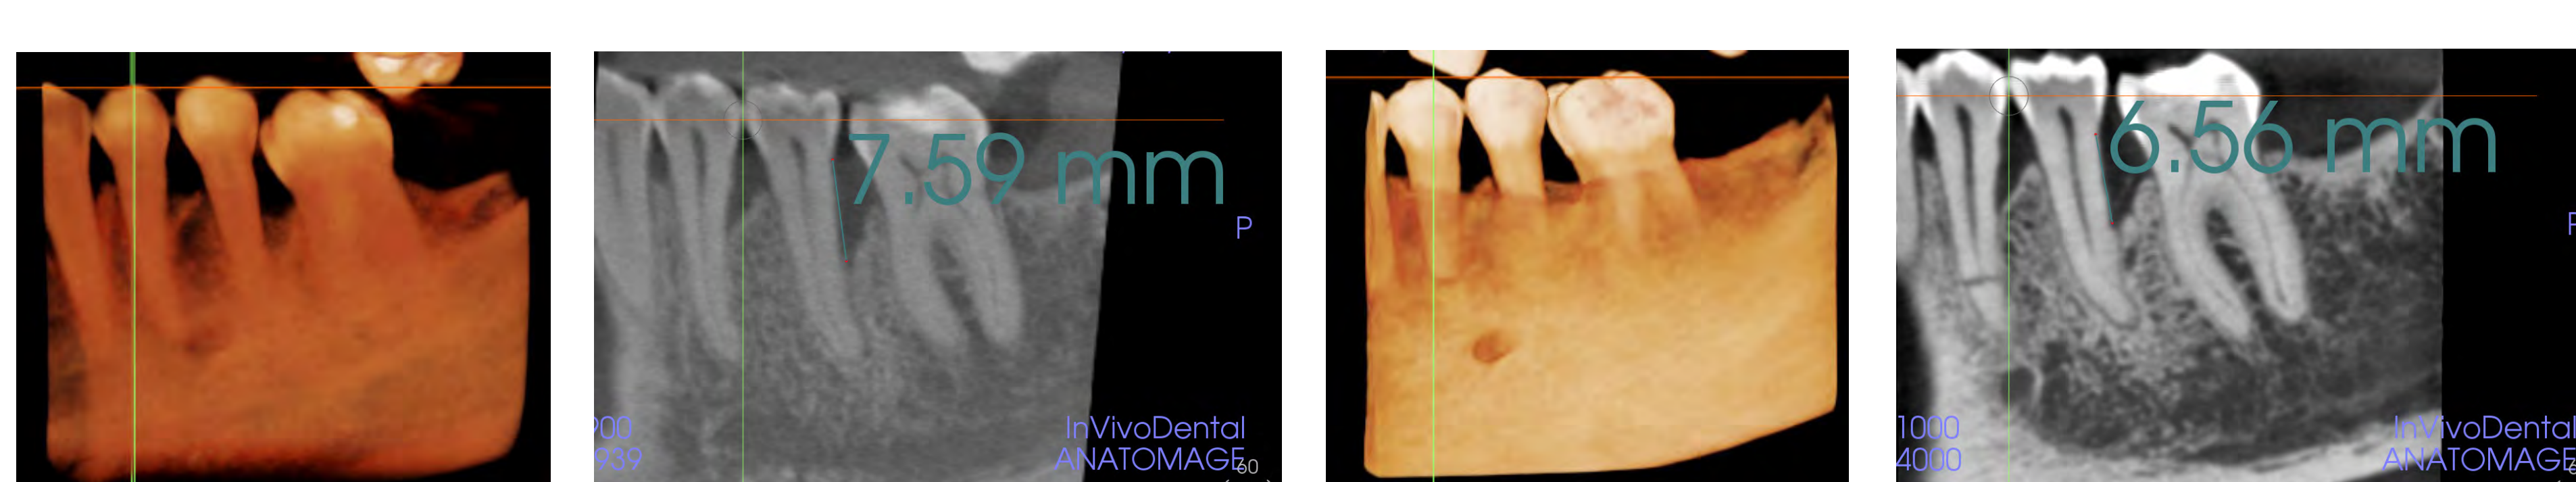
(A) CBCT bony defect distal aspect tooth 20 at T1, SRP+LASER. (B) CBCT defect distal measurement aspect tooth 20 at T1, SRP+LASER. (C) CBCT bony defect distal aspect tooth 20 at T2, SRP+LASER. (D) CBCT defect measurement distal aspect tooth 20 at T2, SRP+LASER.
